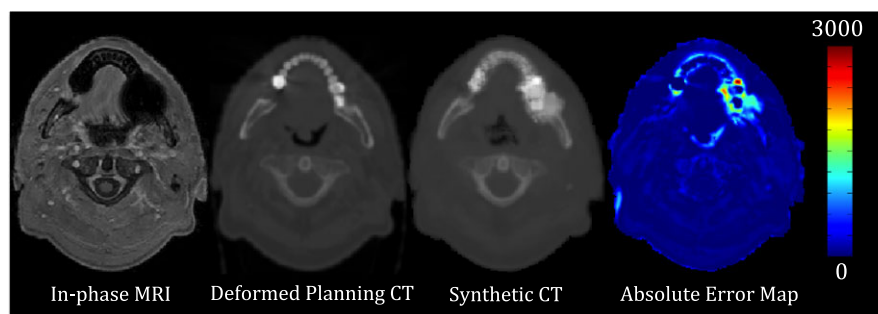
Synthetic CT generation for patient #2 with dental filling and susceptibility artifact. The in-phase MRI, deformed planning CT, synthetic CT, and absolute difference map between the synthetic and deformed planning CT are shown. The presence of dental filling and susceptibility artifact imposed a substantial error in the resultant synthetic CT. [Color figure can be viewed at wileyonlinelibrary.com]
